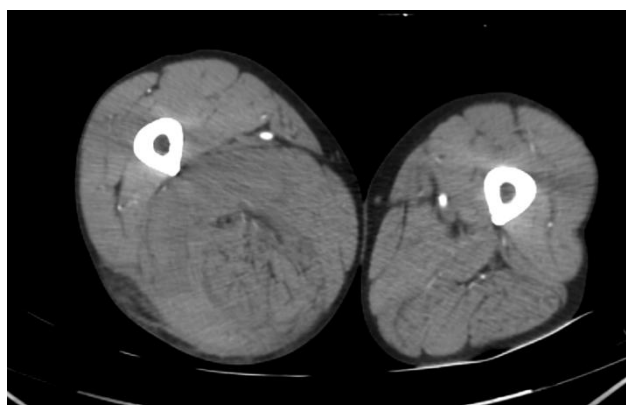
Contrast-enhanced CT of the thighs shows an increase in the volume of the right thigh due to a large hematoma with origin in the popliteal artery rupture.
